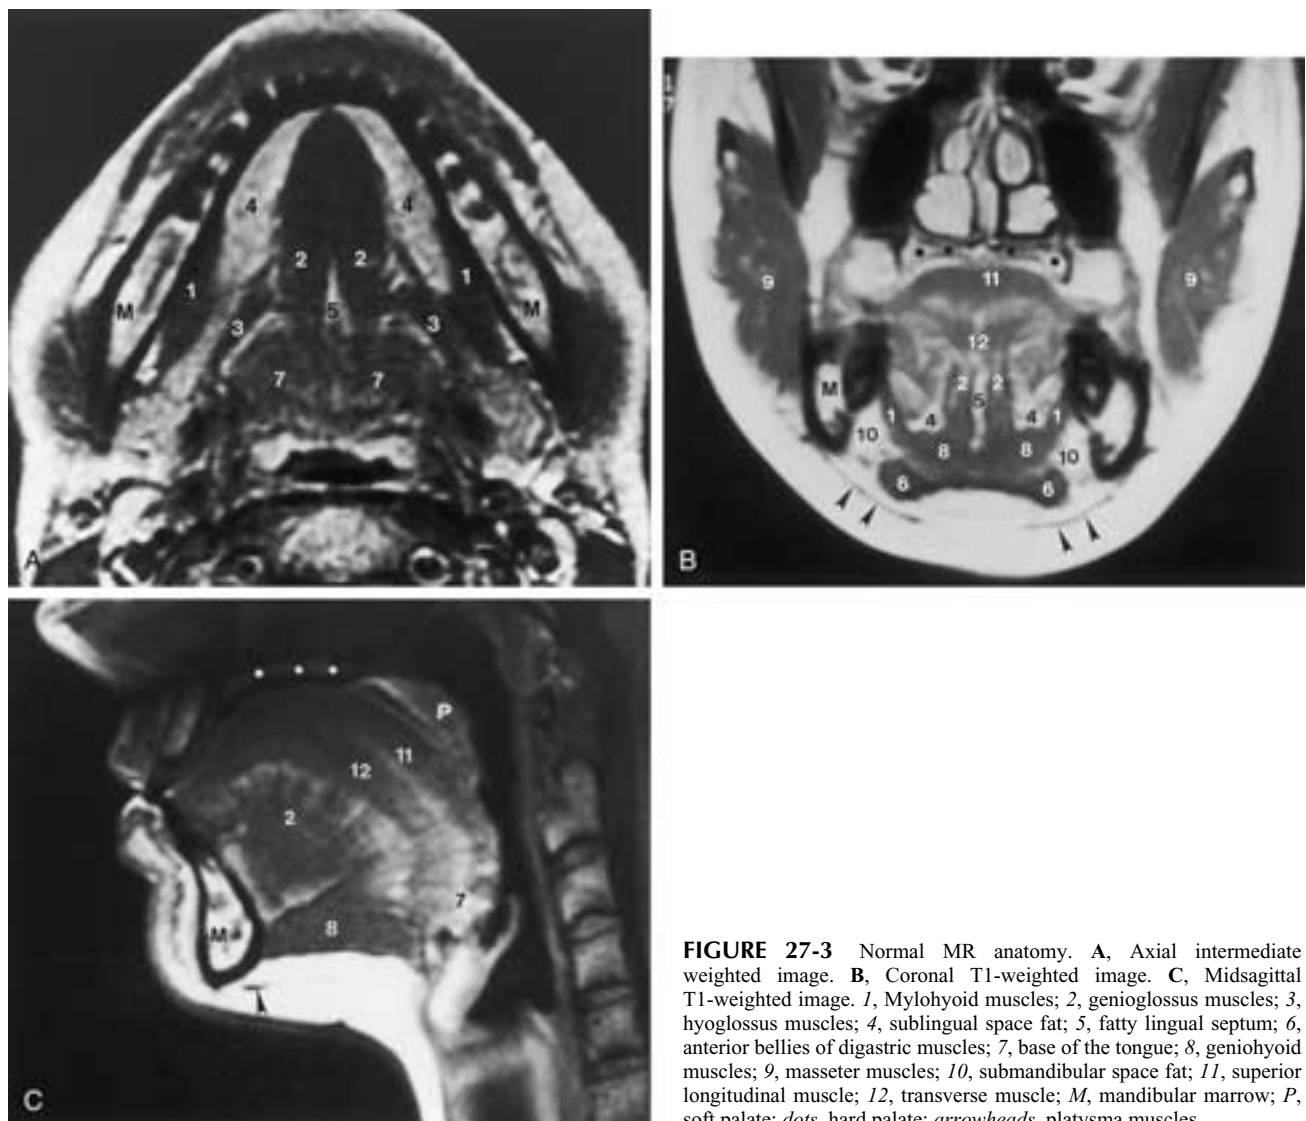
Normal MR anatomy. A, Axial intermediate weighted image. B, Coronal T1-weighted image. C, Midsagittal T1-weighted image. 1, Mylohyoid muscles; 2, genioglossus muscles; 3, hyoglossus muscles; 4, sublingual space fat; 5, fatty lingual septum; 6, anterior bellies of digastric muscles; 7, base of the tongue; 8, geniohyoid muscles; 9, masseter muscles; 10, submandibular space fat; 11, superior longitudinal muscle; 12, transverse muscle; M, mandibular marrow; P, soft palate; *dots*, hard palate; *arrowheads*, platysma muscles.
